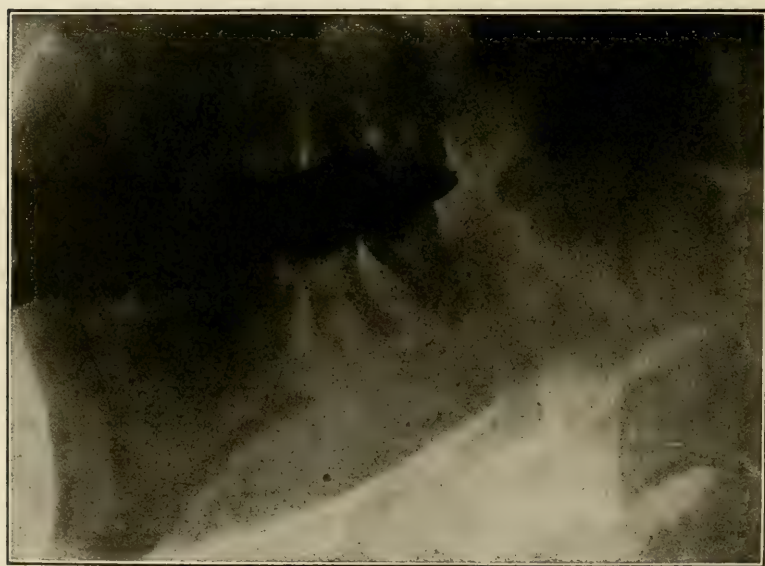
The same as Fig. 286 after reduction and adjustment of an interdental splint. (Radiograph by Pancoast, of Philadelphia.)
